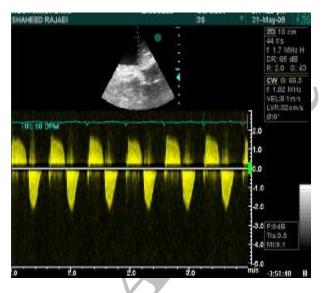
Doppler assessment of systolic and diastolic flow at the site of rupture.
